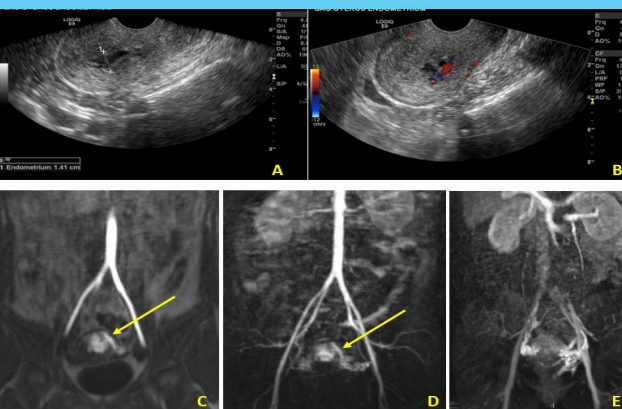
Pre-angiographic imaging. Transvaginal US in greyscale (A) and color doppler (B), and coronal MRA in early (C), mid (D), and delayed (E) phases of enhancement. Tubular hypoechoic structure in a thickened endometrium (A), corresponding to region of increased vascularity on Doppler imaging (B). Subsequent MRA reveals the hypervascular uterine structure (arrow) arising from the left uterine artery, concerning for a vascular malformation based on appearance during different phases of enhancement.
